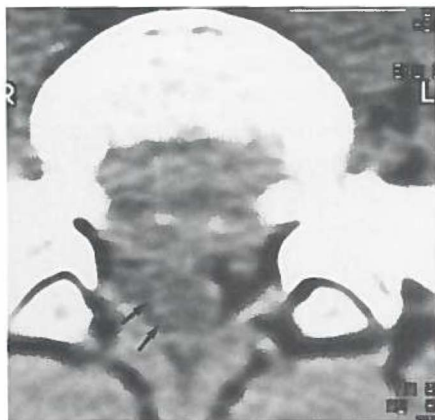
Case 2. CT scan at the same level three months after chemonucleolysis. There is still some asymmetrical disc protrusion on the right with posterior displacement of the right S1 nerve root, but there is more epidural fat (small arrows) and better definition of the dural sac and nerve root on the right.
